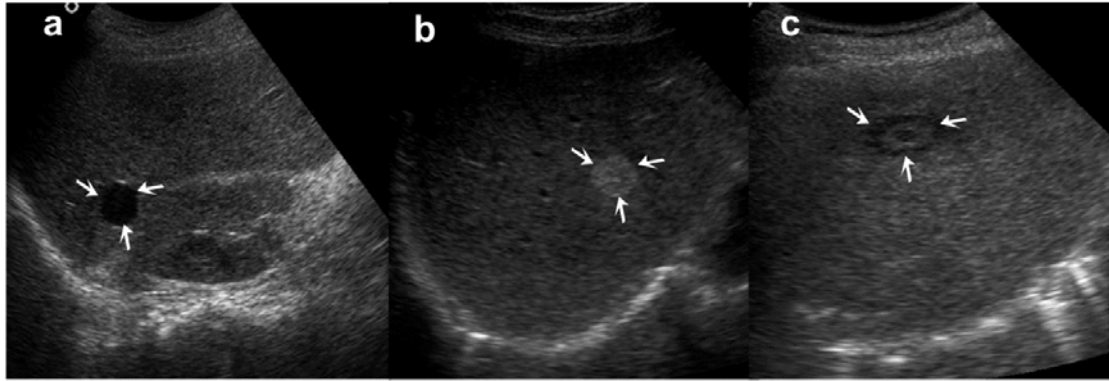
Conventional gray scale ultrasound liver images with appearance of: (a) Typical cyst (thin walled anechoic lesion with posterior acoustic enhancement); (b) Typical HEM (well circumscribed uniformly hyperechoic appearance); (c) Typical MET (*target* or *bull's-eye* appearance i.e. hypoechoic centre surrounded by a hyperechoic rim).
